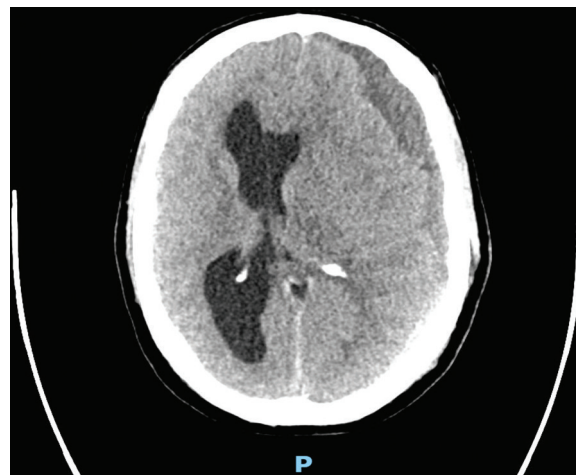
Non-contrast computed tomography of the head showing left subdural hematoma, with rightward midline shift and enlargement of the right ventricular system, and effacement of ambient cisterns with uncal herniation.
